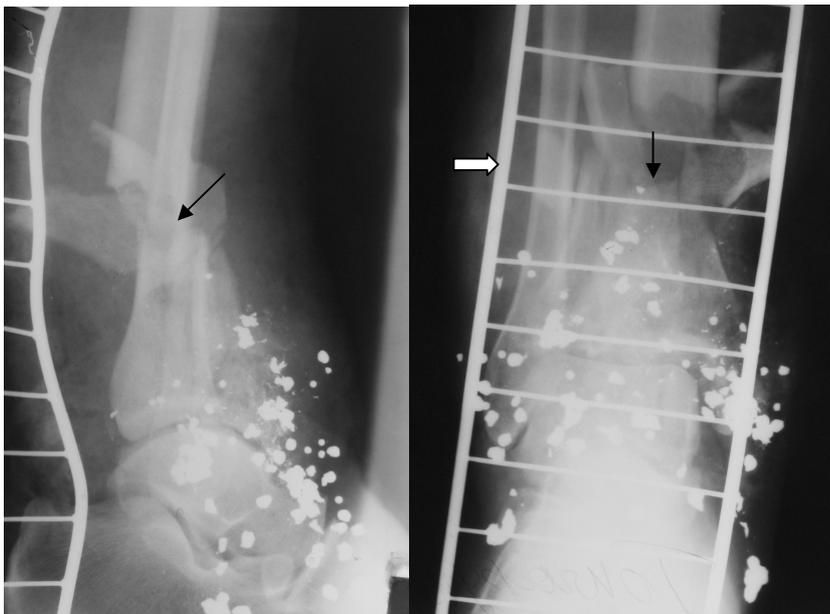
Enlargement radiographs of the shin in direct and lateral projections. In the area of the ankle joint in both projections there are multiple small the round high-intensity foreign bodies (gun shot). Fracture lines in distal thirds of tibia and fibula diaphyses (black arrows), and also in distal metaphysis of the tibia. Numerous bone splinters in the area of the tibia lesion. A wire transport splint (a figured arrow). Fire fractures of shin bones: multisplintered tibia and transverse fibula fractures.
